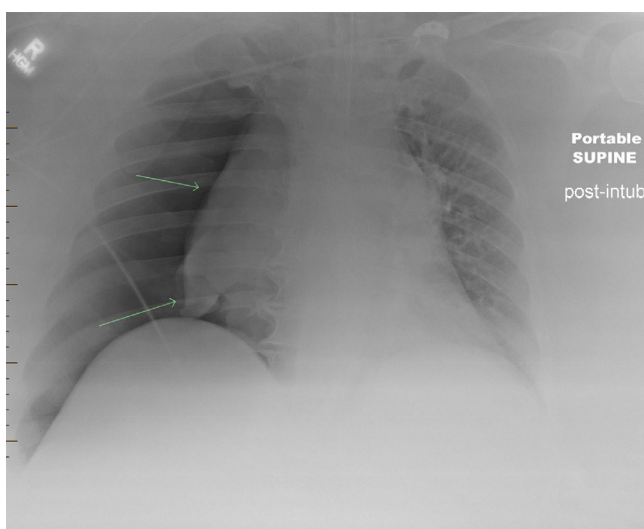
Chest x-ray after intubation demonstrates a large tension pneumothorax.
